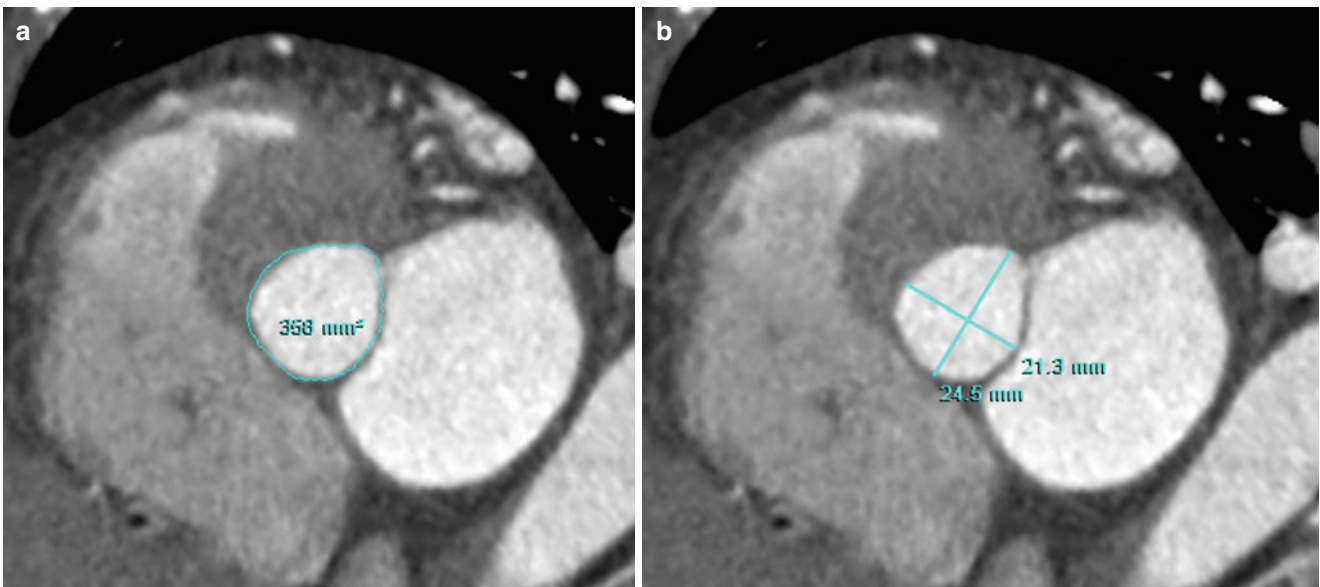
Example of measurement of LVOT area and diameters. (a, b) Double oblique axial images of CT show the measurement of area (a) and diameters (b) of the most narrowed LVOT portion during mid-systole
